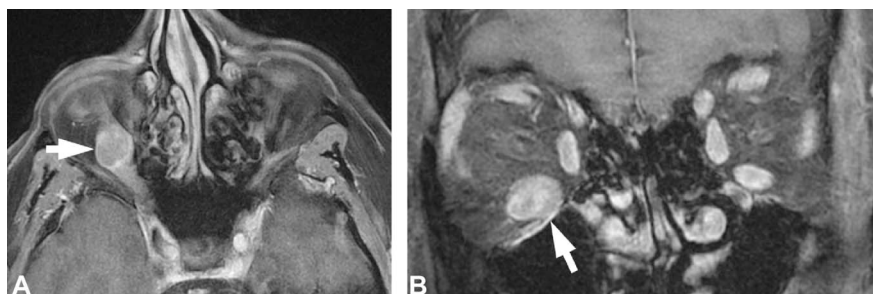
Contrast-enhanced, fat-suppressed T1 axial (A) and coronal (B) magnetic resonance imaging reveals enlargement of the extraocular muscles in both orbits. There is a heterogeneously enhancing mass within the right inferior rectus muscle (arrows).
